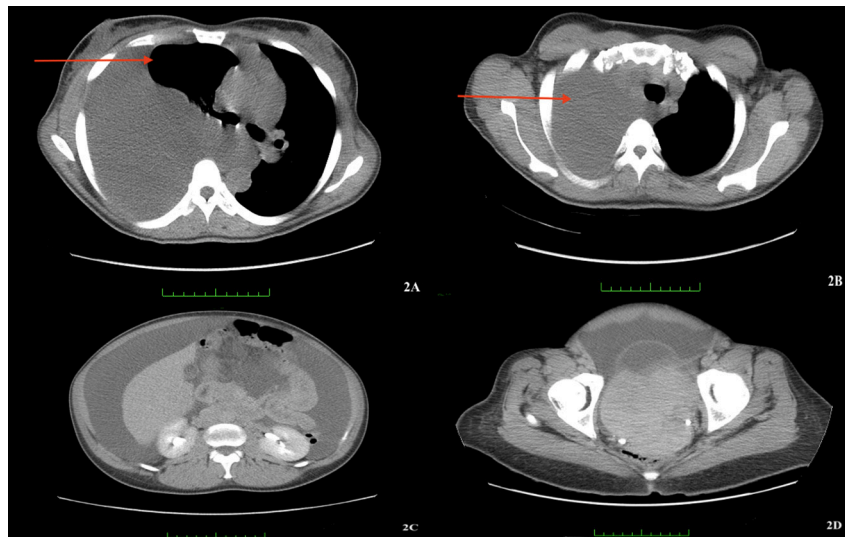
Computed tomography (CT) scan of the chest and abdomen. (2A) Axial thoracic scan demonstrates the collapse of the right lung. (2B) Axial thoracic scan demonstrates massive right-sided pleural effusion. (2C) Axial abdominal scan reveals massive ascites around the liver. (2D) Pelvic scan demonstrates 6 cm adnexal mass, likely an ovarian fibroma.
